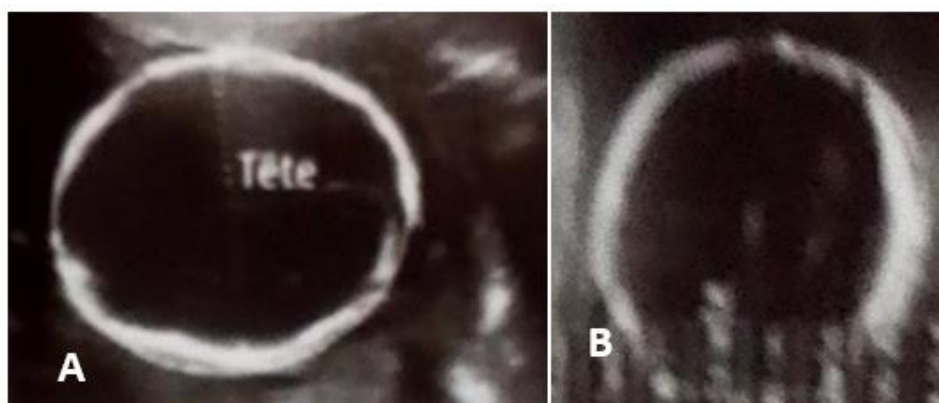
A et B: prenatal ultrasound
